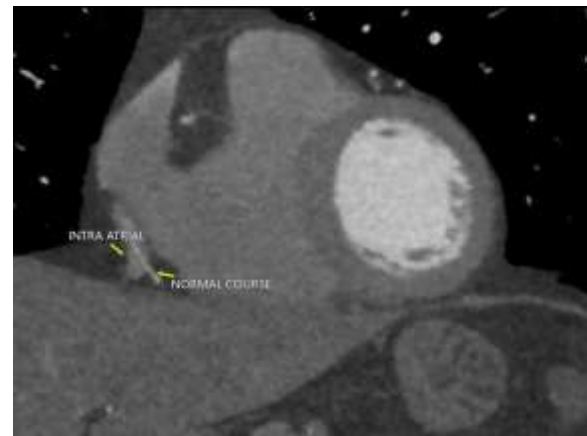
CT Coronary angiography image showing intra atrial course of right coronary artery.
